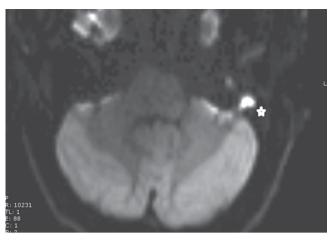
A diffusion-weighted sequence MR image of the cholesteatoma in Fig. 12.8 showing bright signal that represents restricted diffusion. Cholesteatoma marked with a *star*. (Copyright held by Dennis S. Poe, MD, PhD, Boston Children's Hospital)
